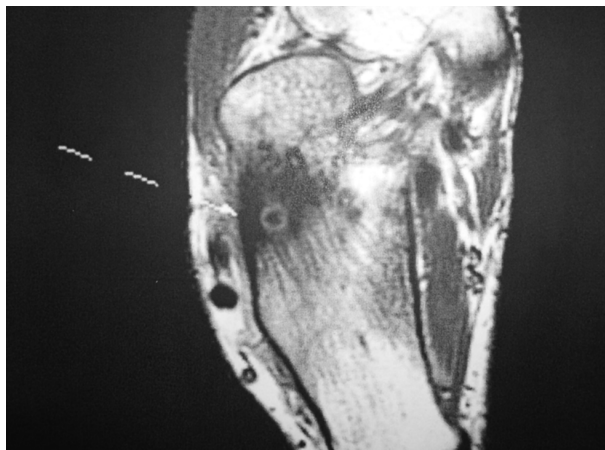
Magnetic resonance image showing 8-mm round lesion near the cortex of the lateral calcaneus with extensive reactive marrow edema throughout the calcaneus.
